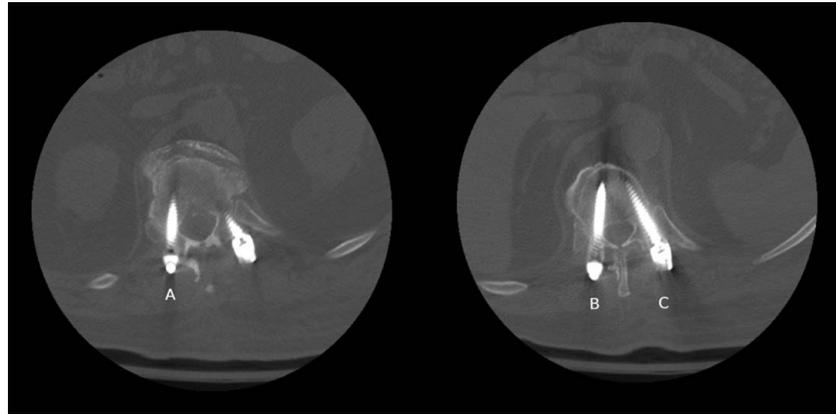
Representative computed tomography images of lower thoracic spine showing grades A, B, and C screws.
